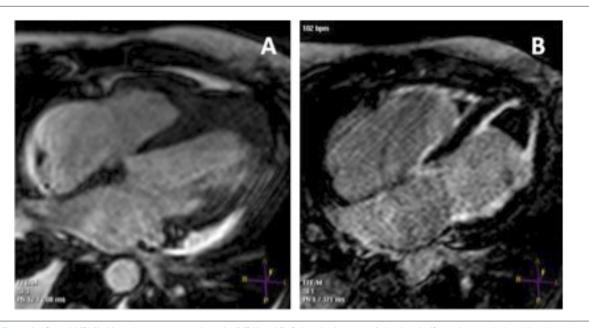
Control MRI [A- Magnetic resonance angiography (MRA) and B- Delayed enhancement] showing significant decrease in thrombi and persistence of endocardial enhancement.
